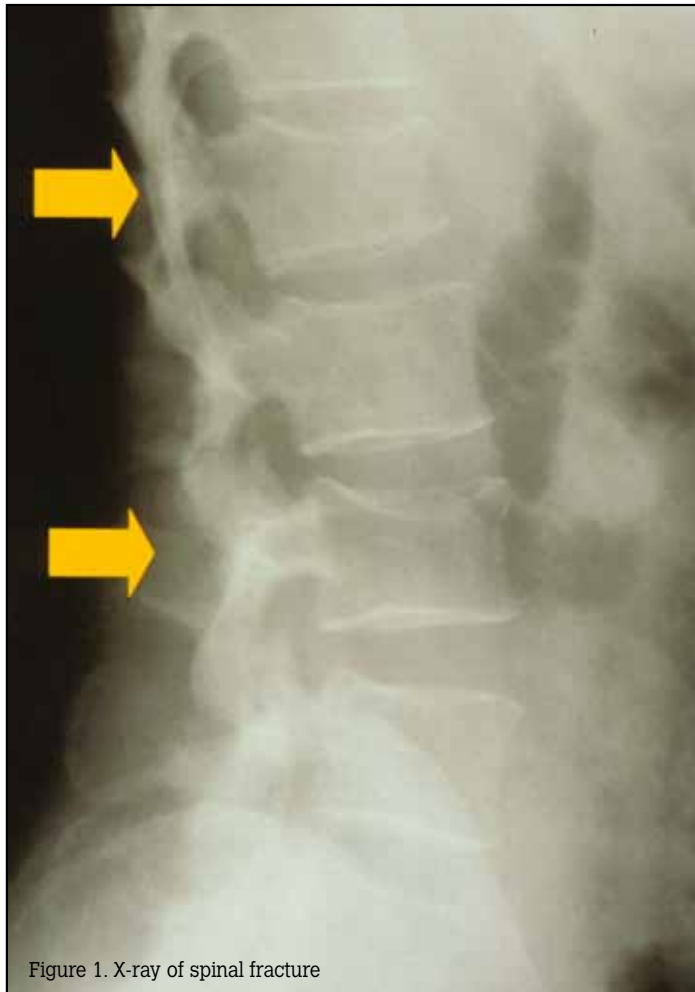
X-ray of spinal fracture
